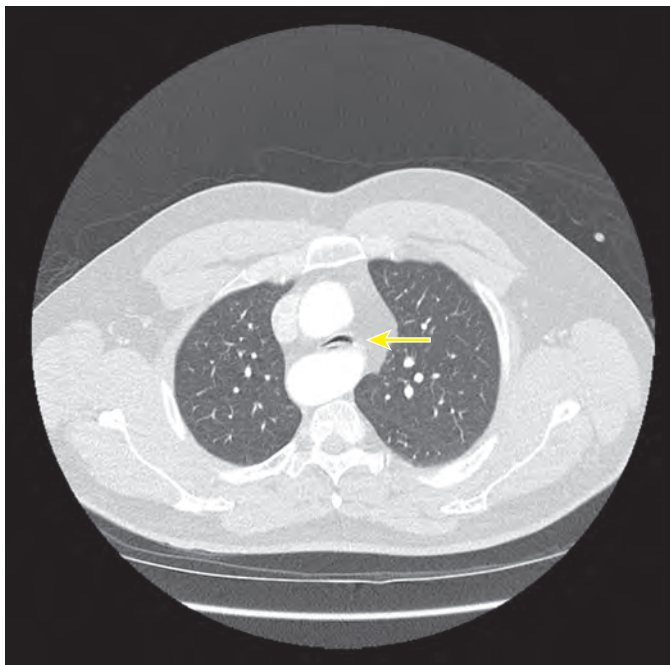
Chest computed tomographic scan of an adult with a Kommerell diverticulum showing mid-distal tracheal compression (yellow arrow). The anterior-posterior tracheal diameter was 3 mm at its narrowest point.
